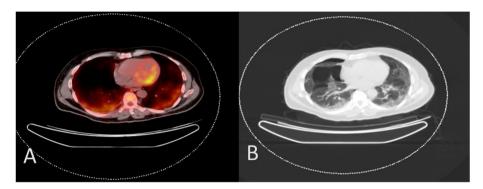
PET-CT findings (dissemated lymphoma lung). PET fusion (Fig. 4A) and PET Lung parenchyma (Fig. 4B).
